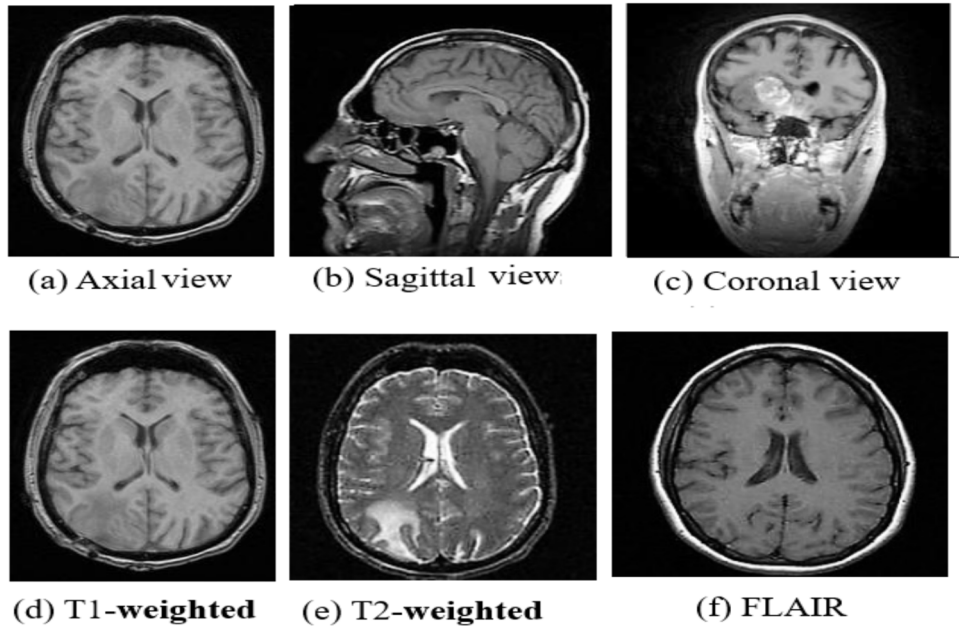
Various MRI images sequences [29]
